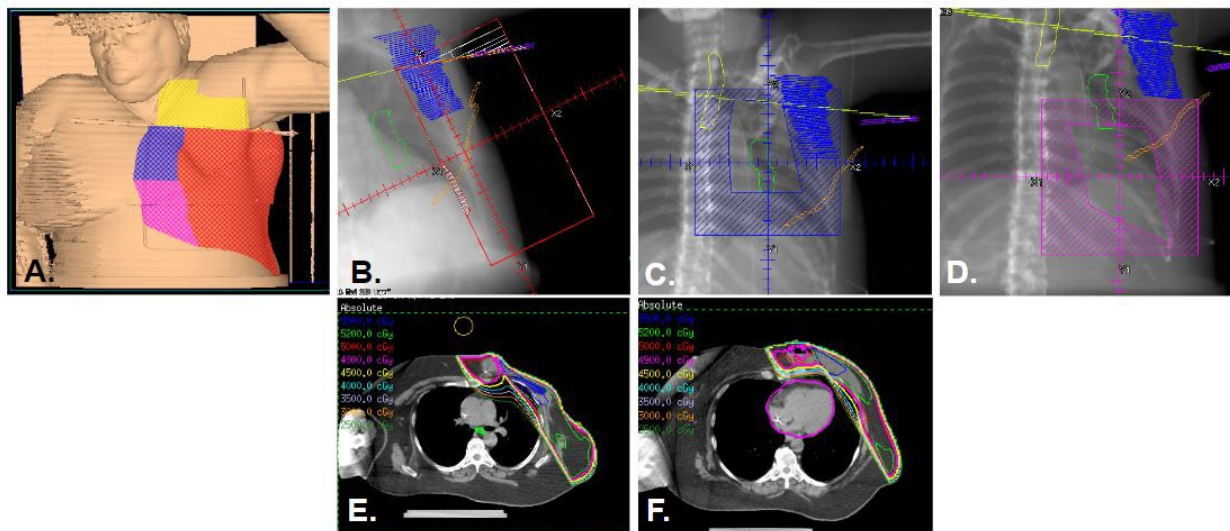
Partially wide tangent technique for treating internal mammary nodes. A. Projection of fields on skin. The red field represents the partially wide tangent, which extends slightly beyond midline. B. Digitally reconstructed radiograph showing tangent fields, which cover internal mammary nodes in first 3 intercostal spaces (shown in orange). Surgical scar shown in pink. Isodose distributions shown in upper (C) and lower (D) chest wall.
